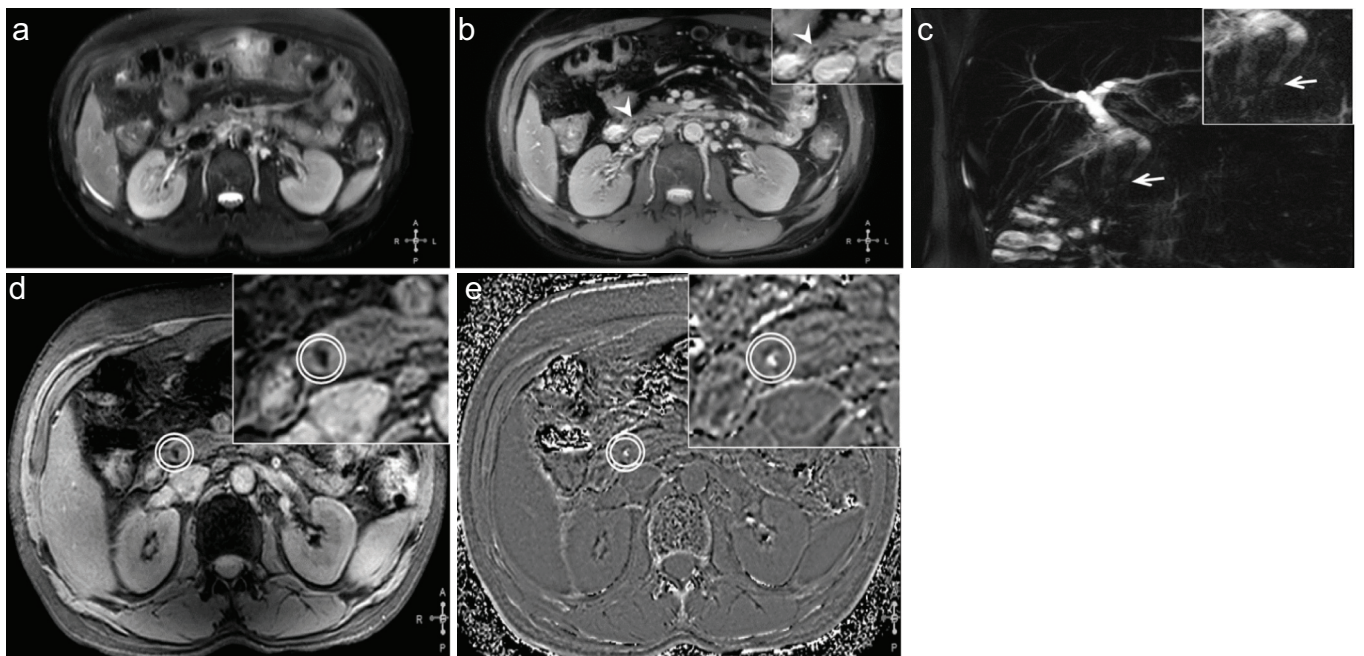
a-e. SWI improved diagnostic confidence—comparative collage of images from the same anatomical level, from one of the patients where SWI data provided improved diagnostic confidence for CBD stone identification. T2-weighted image (a) is not indicative. BTFE (b) indicates possible calculus, and MRCP (c) data indicates a filling defect and possible sludge. In comparison, SWI data (d, e) clearly demonstrated the calculus with hypointense signal in magnitude and hyperintense signal in phase (e) images in the corresponding region.
